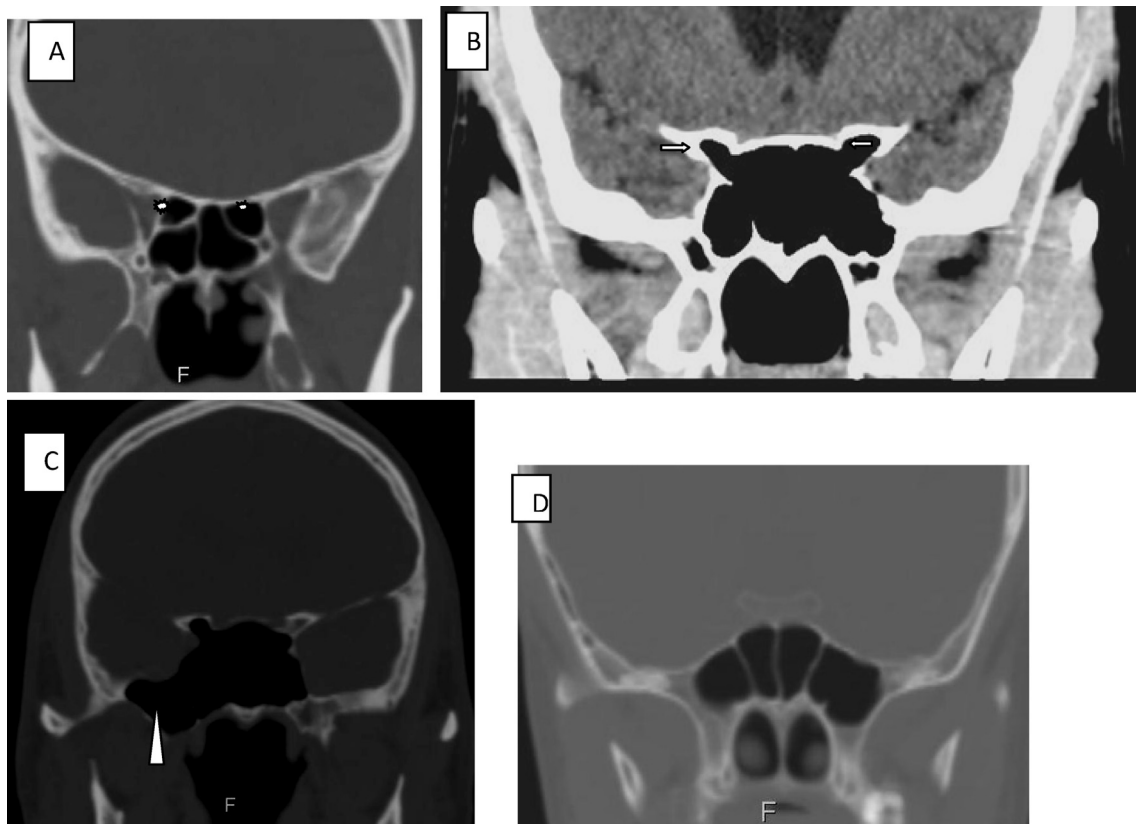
Coronal CT images shows (A) Onodi cells (explosion), (B) extension into the anterior clinoid process bilaterally (arrows), (C) extension into the right pterygoid plate (arrow head) and (D) multiple sphenoid sinus septations.
